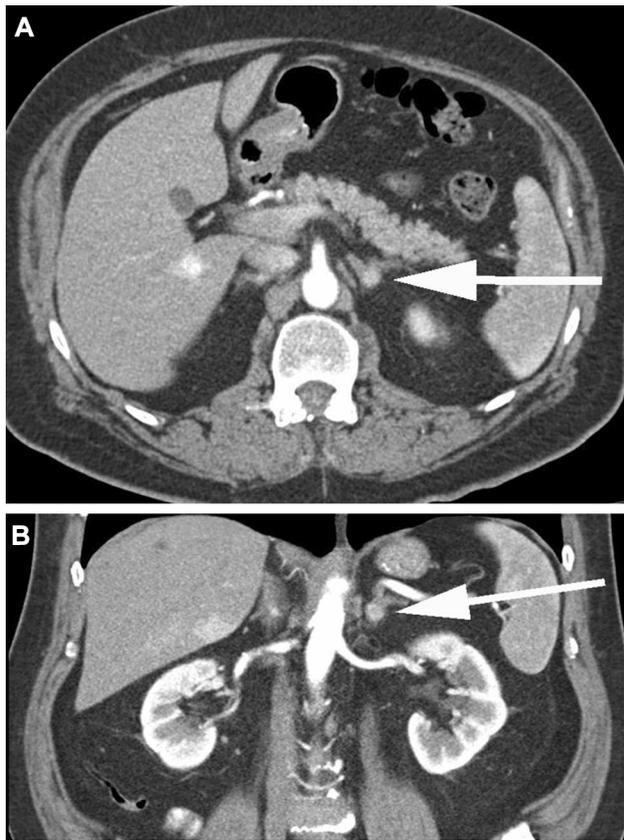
58-year-old man with hypertension, von Hippel Lindau syndrome and a pathologically proven 9 mm left adrenal pheochromocytoma identified on renal protocol CT. Axial arterial phase CT image (a) and coronal arterial phase image (b) demonstrate a small hypervascular left adrenal nodule (arrow), which measured 102 HU on the arterial phase
